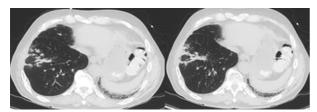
High-resolution computed tomography showing multiple nodular opacities.
